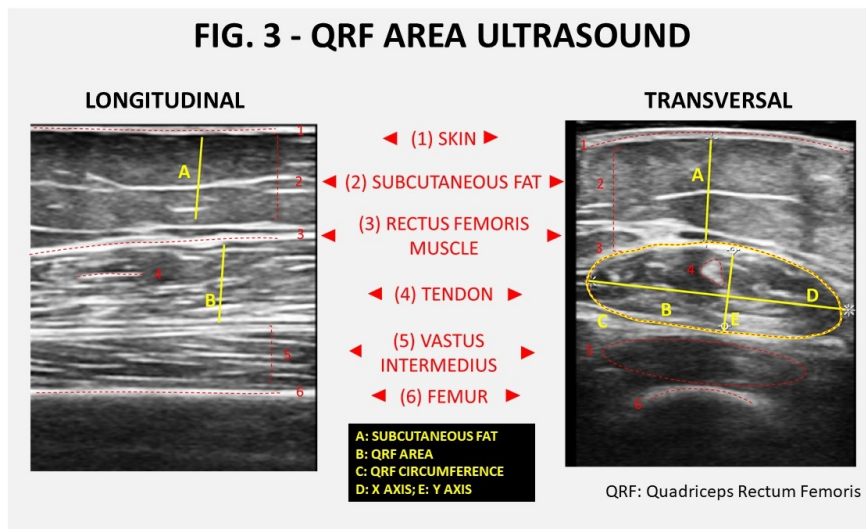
Comparison of longitudinal and transversal sections of the QRF muscle area ultrasound. Functional measures and main anatomical structures are represented.
